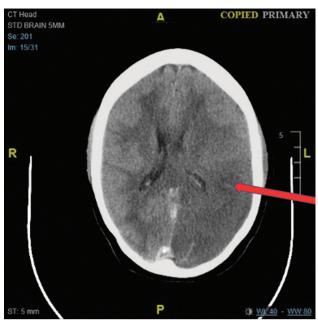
Case 2 repeated computed tomography showing diffuse left cerebral hemisphere infarction.
